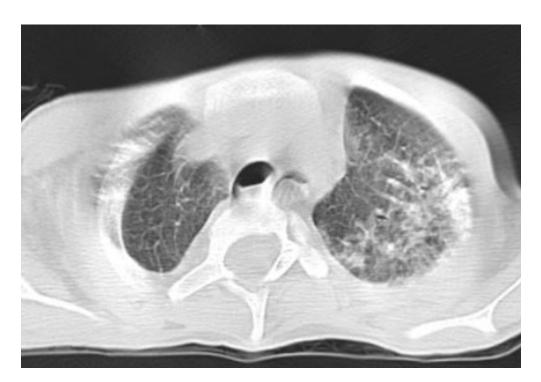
chest CT of patient number 10
